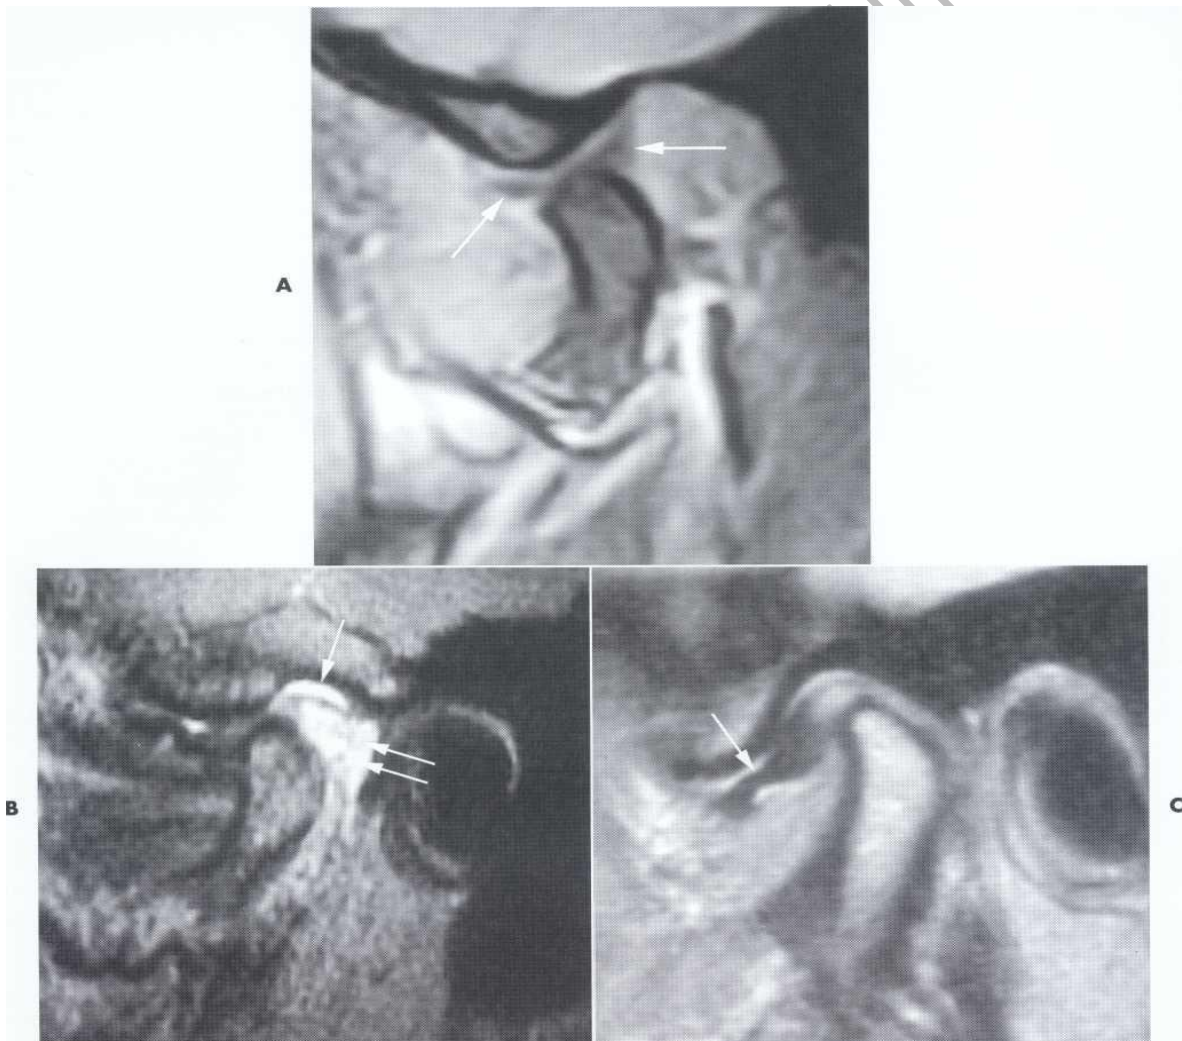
A, T1 -weighted MR image of the TMJ.. B, T2-weighted MR image C, the disk is anteriorly displaced (arrow), with the posterior band in the 9 o'clock position relative to the condylar head.
